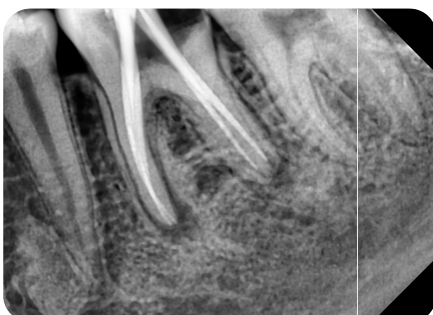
Master cone radiograph revealing the presence of additional root distolingually
